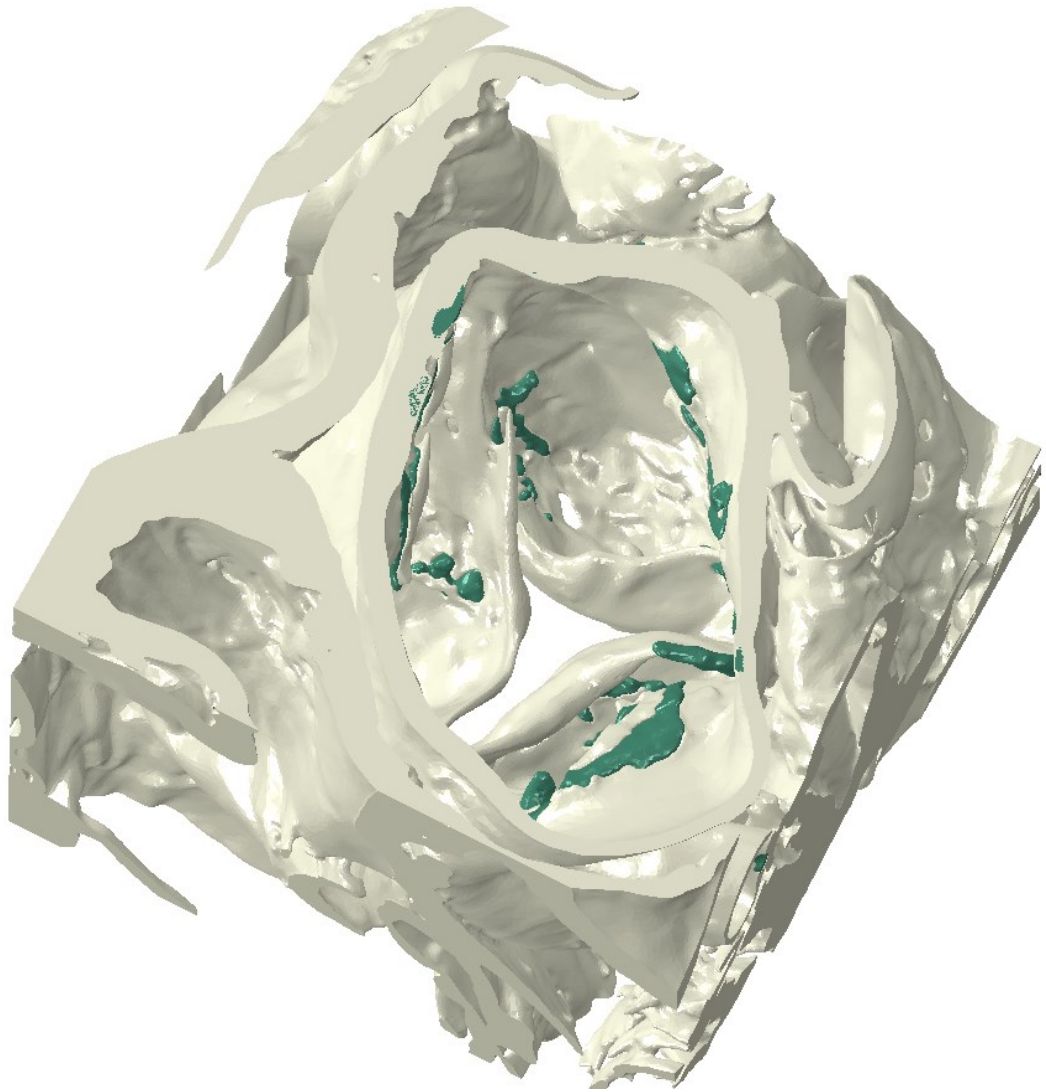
High resolution model of an aortic root derived from μ CT data. The aortic root is orientated such that the aortic valve leaflets are visible through the aorta. The green regions are calcified plaques.
